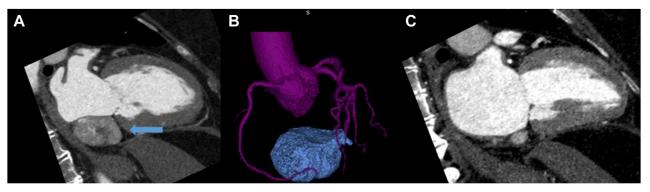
(A) Cardiac computed tomography scan, 2-chamber display, demonstrates the retroatrial, intrapericardial mass (*arrow*) with compression of a poorly visualized coronary sinus. (B) Volume-rendered three-dimensional reconstruction of the coronary supply to the retroatrial mass. (C) Two-chamber display after surgical resection demonstrates normal retroatrial anatomy.
